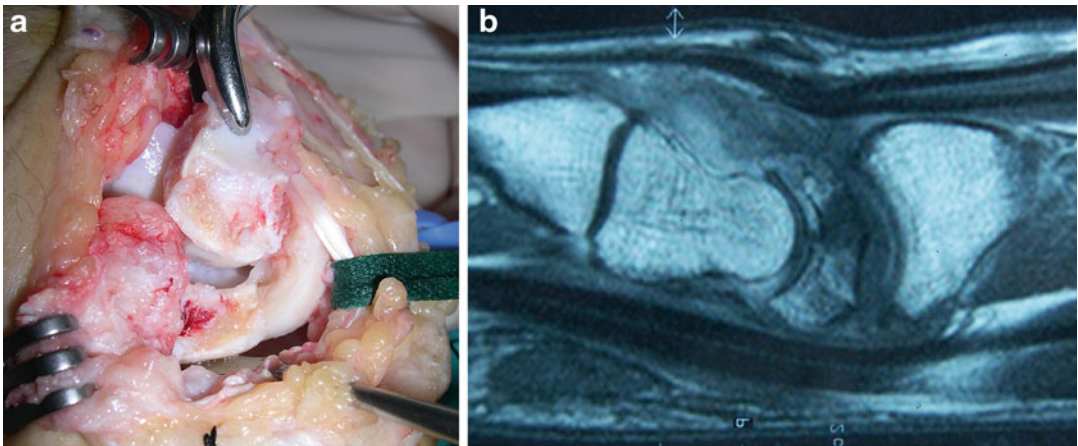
(a) Once the lunate is divided in dorsal (D) and volar (V) fragments, “bleeding points” appear only in the distal-ulnar corner (*arrow*). (b) Differences in residual vascularity reflected in MRI
